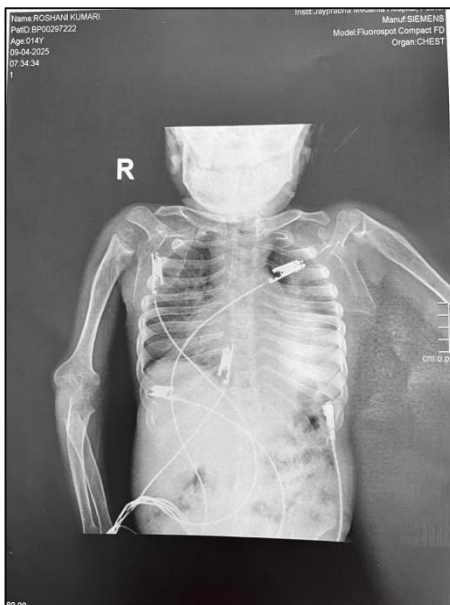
Chest radiograph showing cardiomegaly with paddle-shaped ribs, thickened clavicles, and vertebral abnormalities consistent with dysostosis multiplex.
